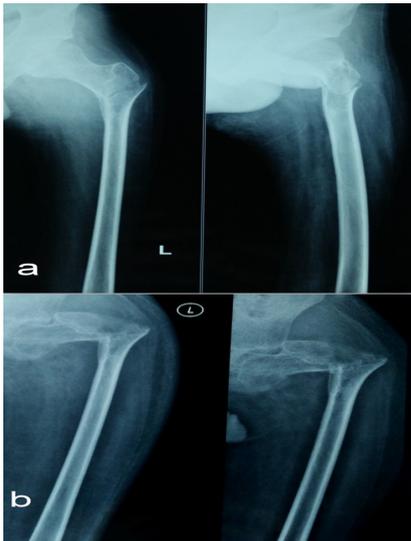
The radiograph of a subtrochanteric fracture in polio limb (a) managed conservatively to union in varus (b).
